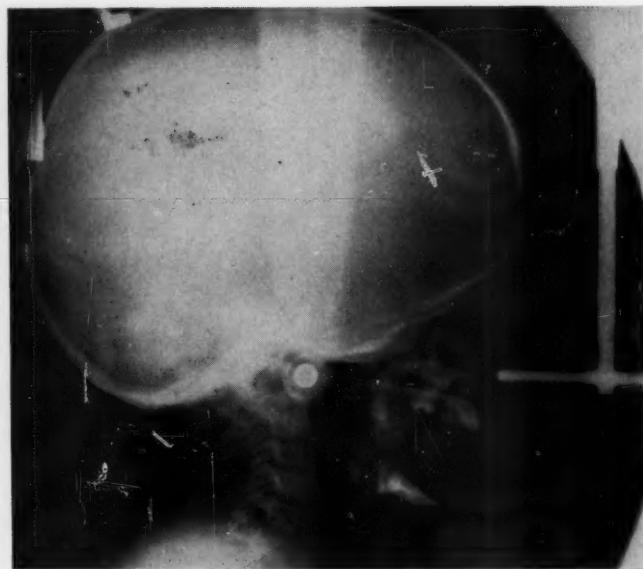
Roentgenogram of Patient L. E., aged 12 years 3 months.
